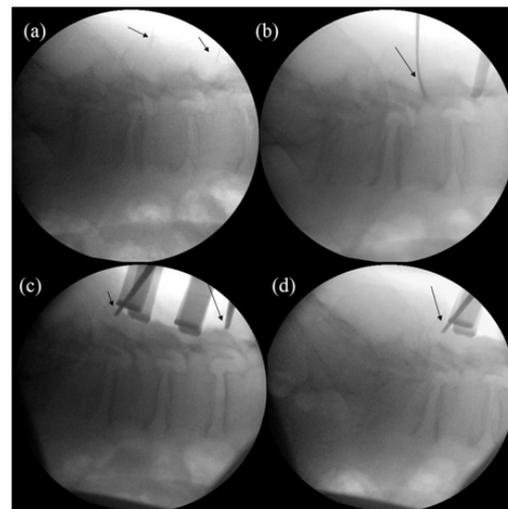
Preoperative (Step 1) X-ray (a) Shows Needles (Arrows) at Superior and Inferior Margins of Planned Multilevel Decompression. Intra-operative (Step 2) X-ray (b), Confirms the Level by the Needle (Arrow). Intra-operative (Step 3) X-ray (c) Shows Hooks (Arrows) at the Superior and Inferior Margins of Decompression, However, the L5/S1 Junction is Not Included. Intra-operative (Step 3) X-ray (d) Shows Hook (Arrow) at the Inferior Margins of Decompression, the L5/S1 Junction is Now Included, thereby Confirming the Exact Level of Decompression.
